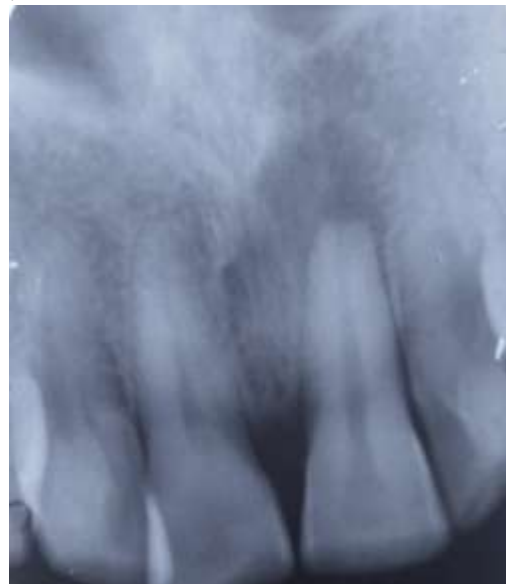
PRE – OP RADIOGRAPH
